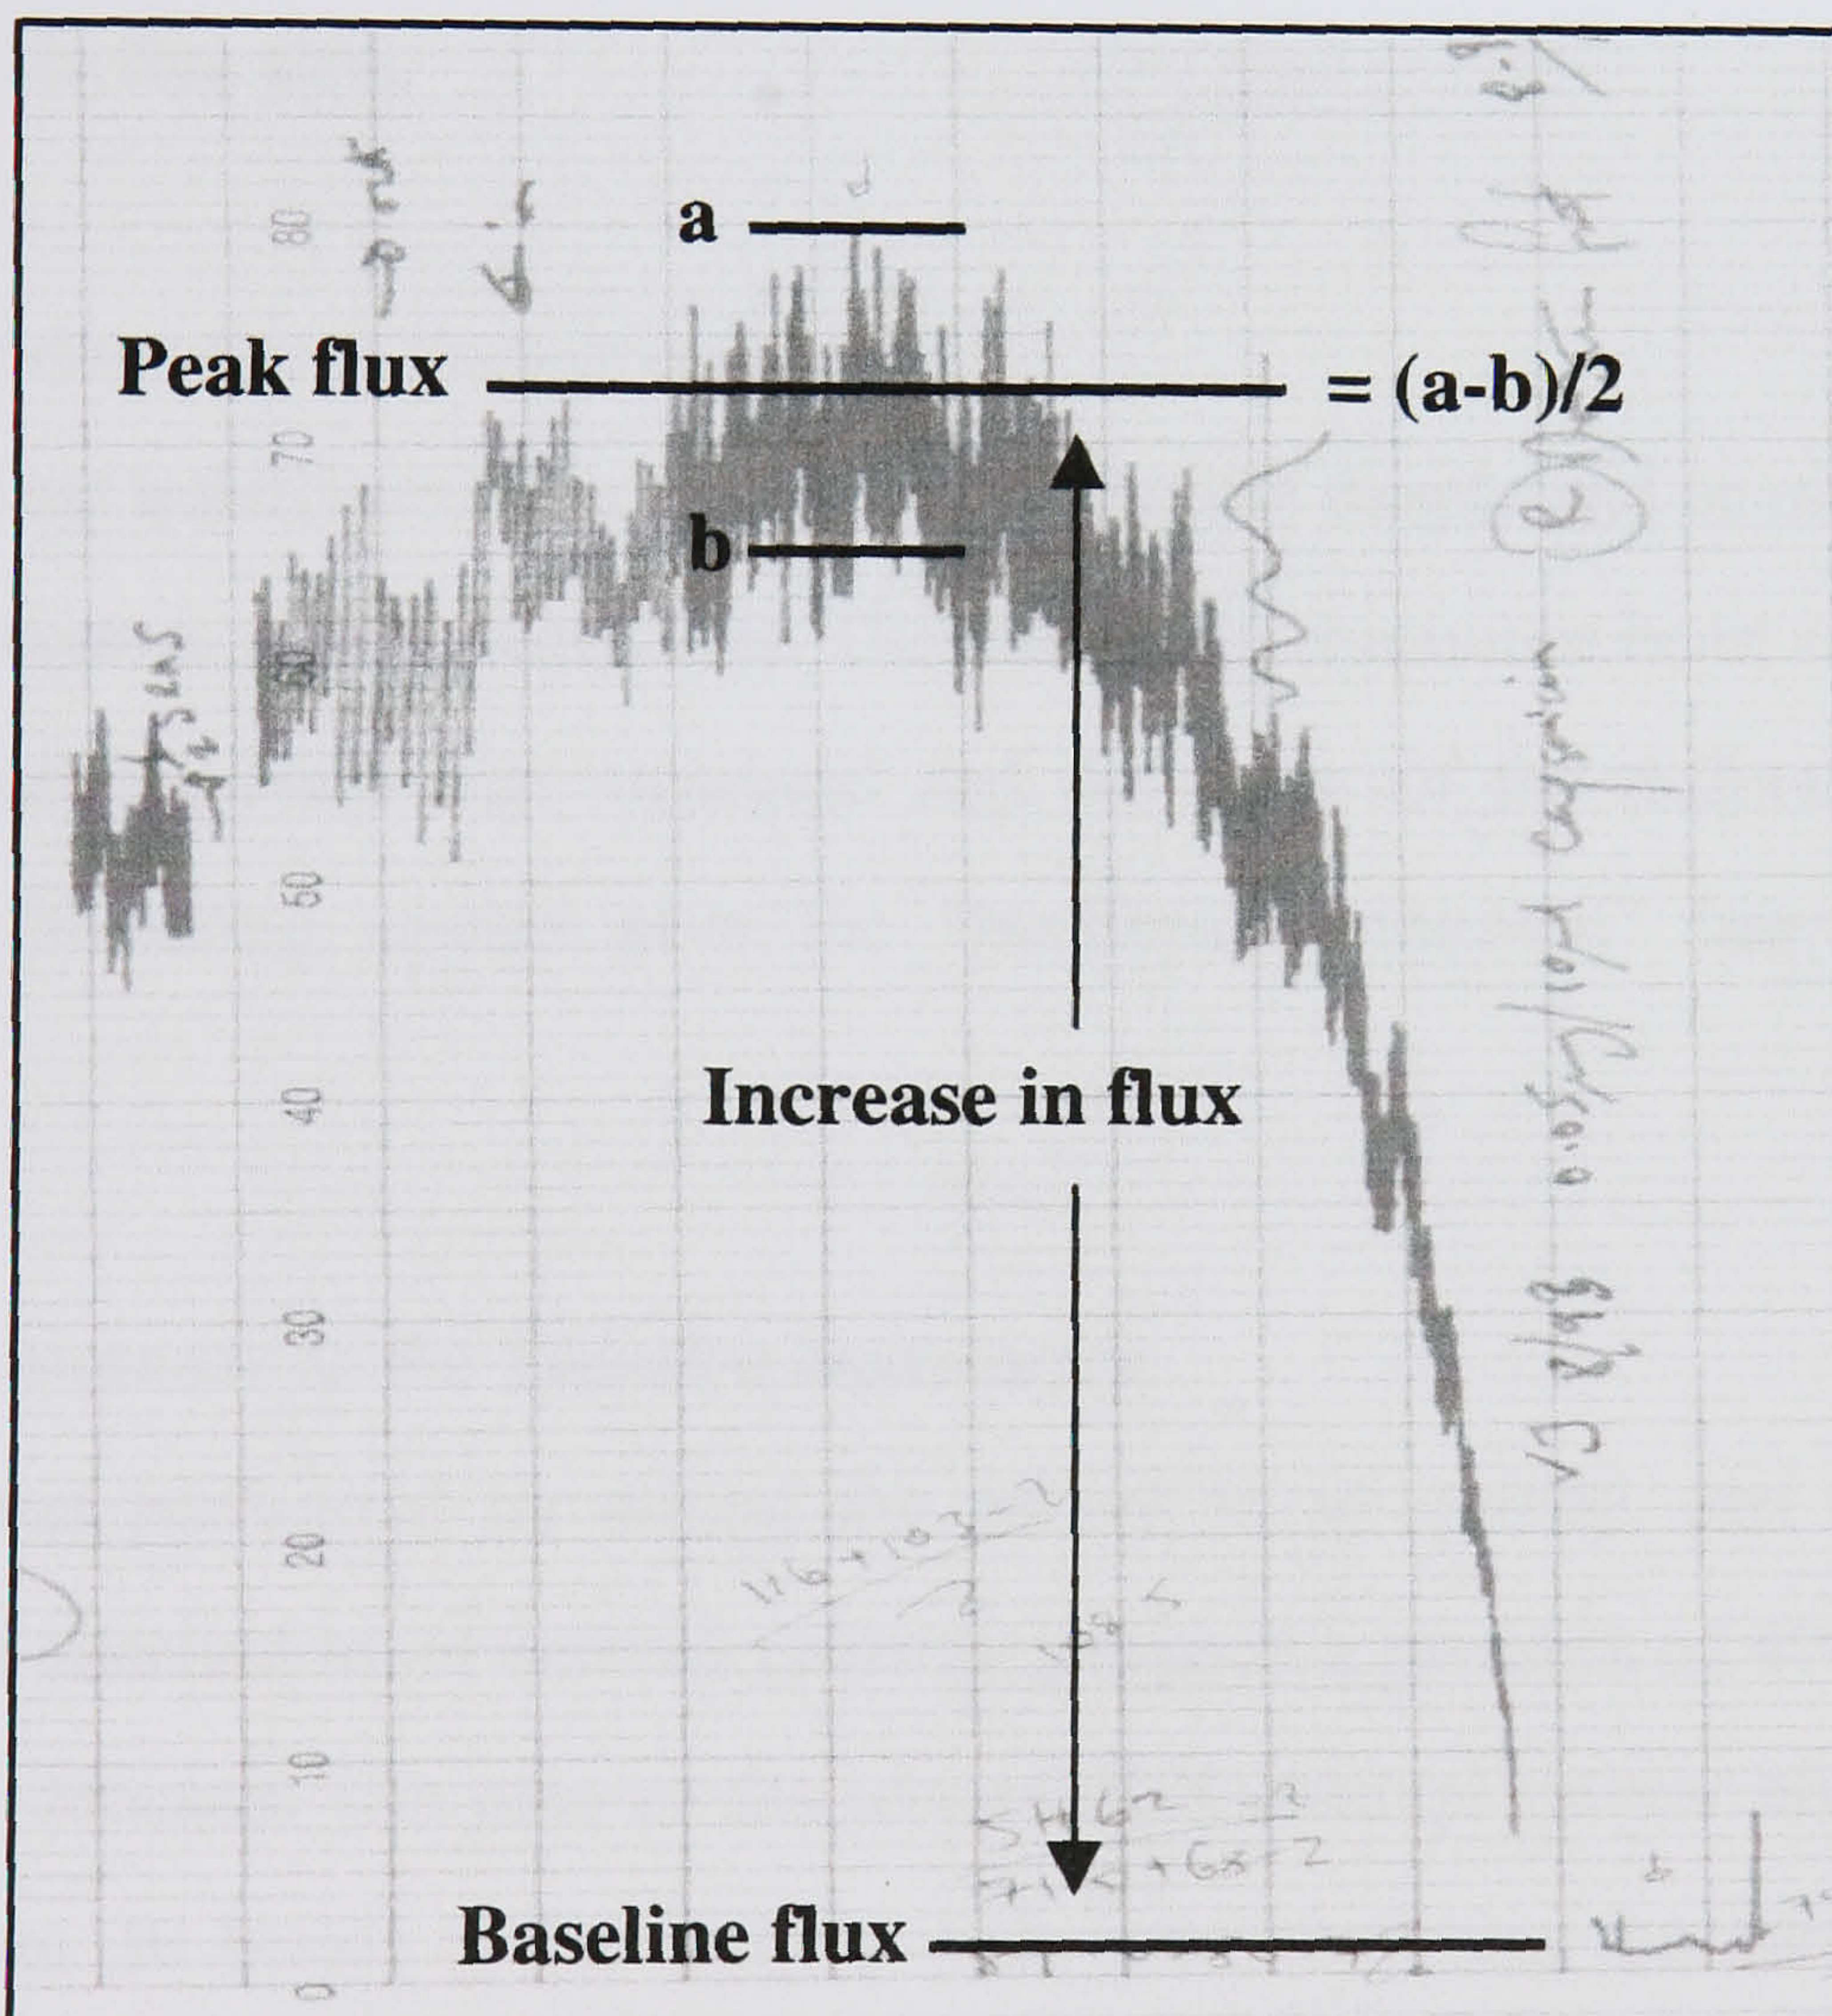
Axon-reflex vasodilatation. (a) This was induced by injection of intradermal capsaicin ($0.05 \mu\text{g}$ in $10 \mu\text{l}$), as this selectively activates nociceptive fibres. (b) The immediate increased capillary flux as a result of vasodilatation was measured with a laser-Doppler = $[(a-b)/2] - \text{baseline flux}$.
